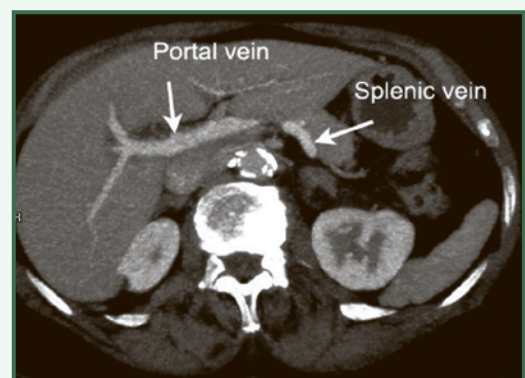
A normal patient CT scan with patent portal vein for comparison
